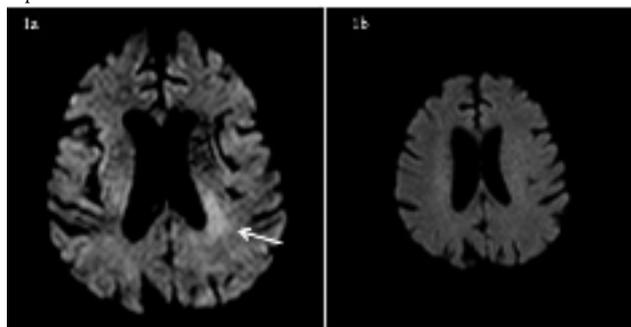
Acute restricted diffusion around left ventricular posterior horn Figure 1b: Normal diffusion-weighted MR image
